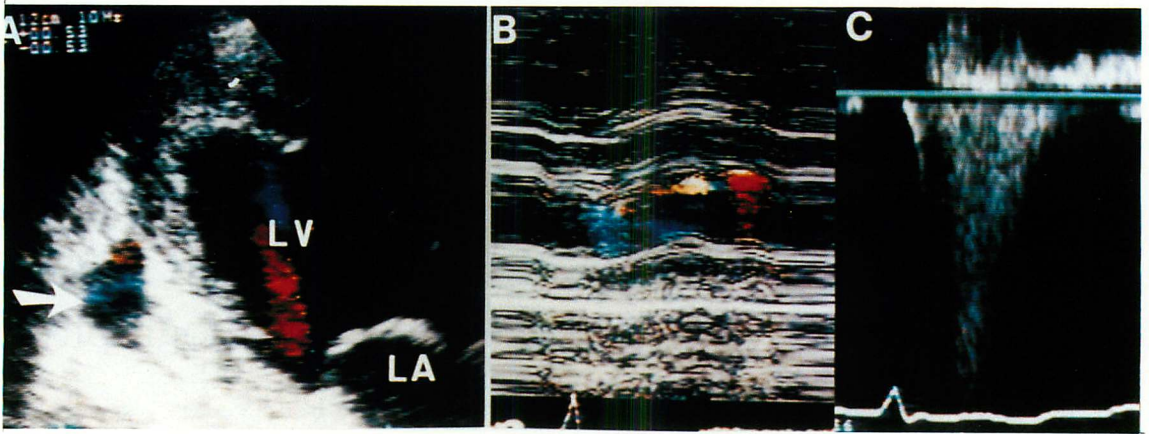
Two-dimensional and Doppler echocardiograms of myocardial perforation induced by trocar catheterization.
